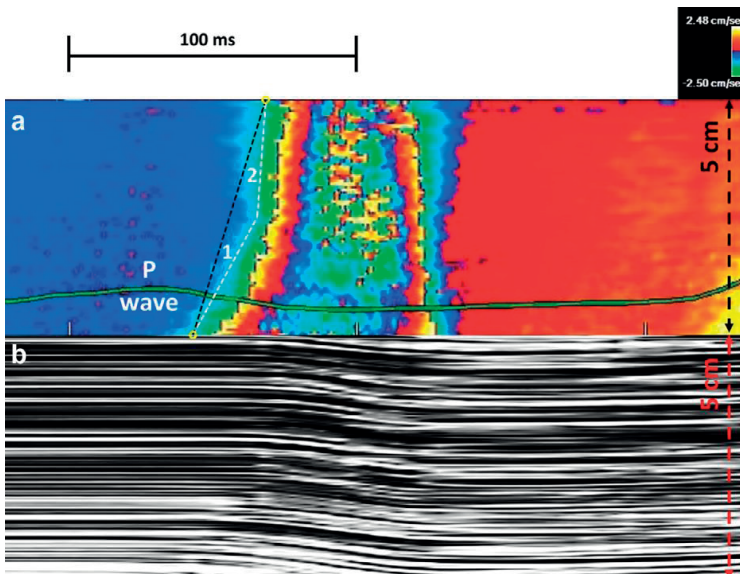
In more than 40% of the patients with hypertrophic cardiomyopathy, a non-constant shape of the initial front could be seen. (a) Tissue Doppler imaging velocity pattern. The straight line between the entry and exit points of the MSPa into the M-mode map (black dotted line) emphasizes the deviation of the first isovelocity front (white lines) from a constant propagation velocity. The first milder slope is marked '1' and the second steeper slope is marked '2'. (b) Anatomic M-mode of the underlying 2-D information along the same M-mode line, revealing the same variation in propagation velocity.
